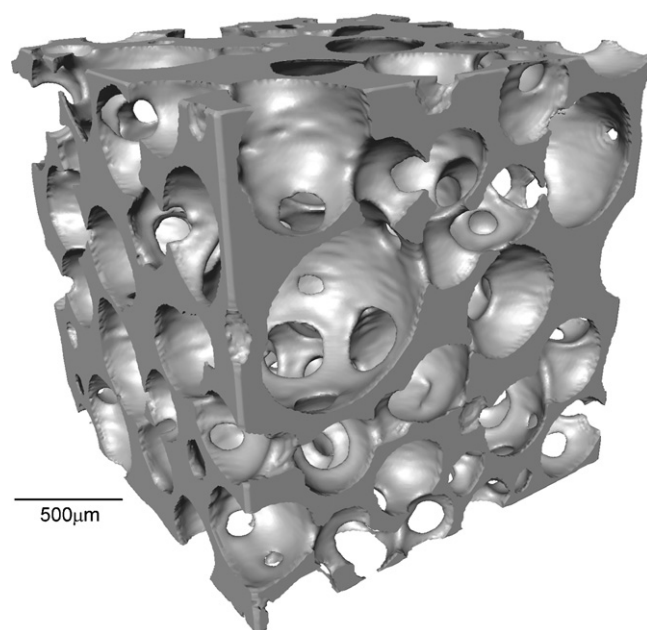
$\mu\text{CT}$  image of a bioactive glass foam scaffold. Courtesy of Gowsihan Poologasundarampillai, Imperial College London.
